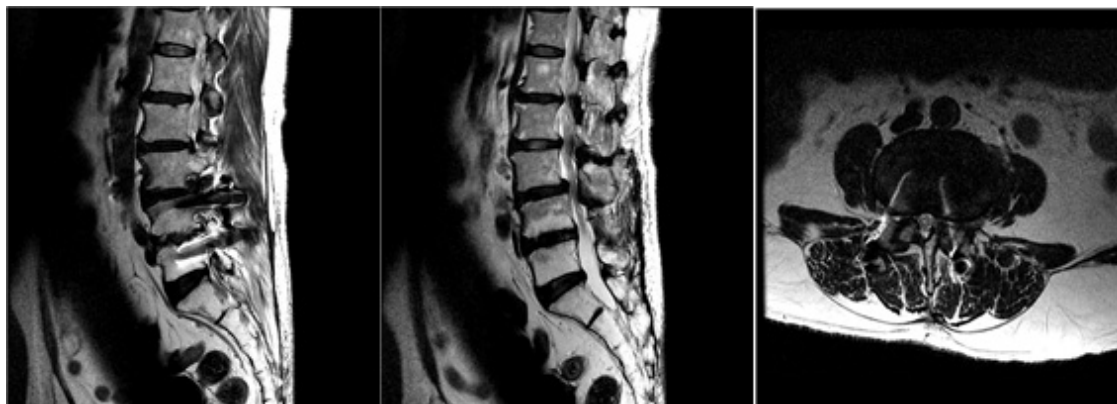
2014/02/25, Lumbar MRI sagittal image, L3-L4 axial image
